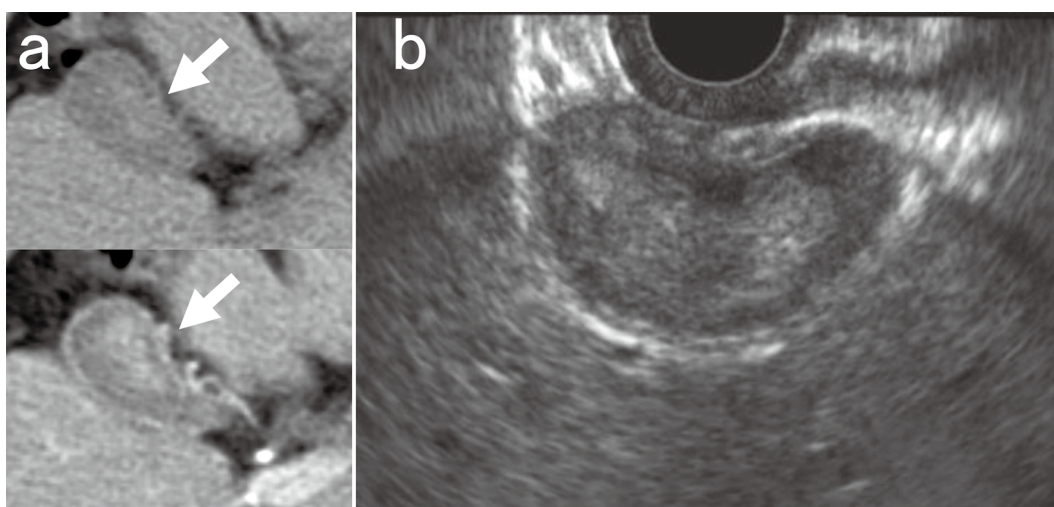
a: Contrast-enhanced computed tomography at our hospital revealed a wide-based 10-mm-diameter tumor (arrow) with a contrast-enhanced effect in the gallbladder. The upper image shows the non-contrast phase, whereas the lower image shows the contrast-enhanced phase. The gallbladder tumor was also confirmed in the non-contrast phase on computed tomography. b: Endoscopic ultrasonography revealed a distorted gallbladder tumor suggestive of cancer that did not progress to the liver.
